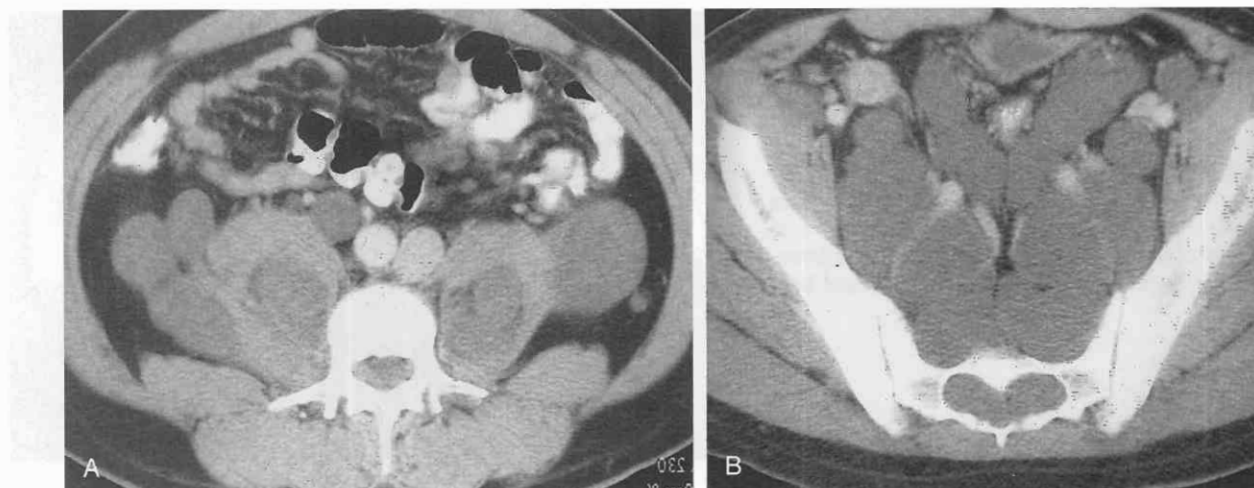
Plexiform neurofibromas in a 28-year-old man with type I neurofibromatosis. *A*, Low-attenuation masses are identified on this contrast-enhanced CT image within and lateral to the psoas muscles. *B*, A more caudal CT scan reveals plexiform neurofibromas in the presacral space in the pelvis as well as within the spinal canal. Neurofibromas in the spinal canal are expanding the sacral foramina.
